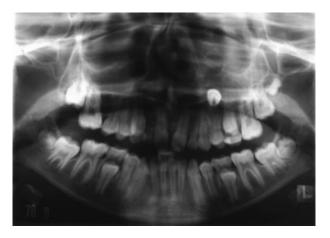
Pretreatment panoramic radiograph showing grossly ectopic 23.
